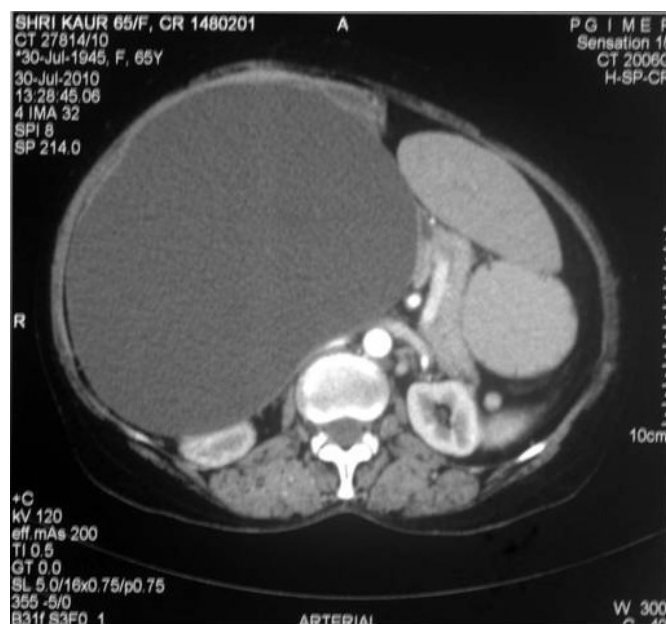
Contrast-enhanced CT scan of the abdomen showing a 19 cm x 15 cm x 12.5 cm cystic mass in the V, VI and VII segment of the right lobe of the liver, extending into the hepatorenal fossa and compressing the right kidney.
